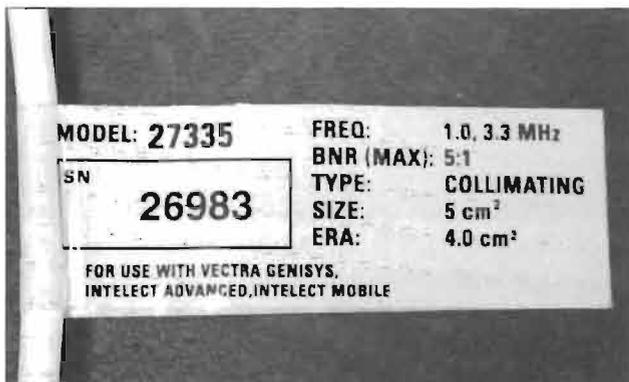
FDA Labeling Requirements for Therapeutic Ultrasound. The sound head pictured here is capable of producing an output frequency of 1 or 3.3 MHz and has an effective radiating area of 4.0 cm². Note that the BNR is listed as 5:1 for both outputs. The "Max." indicates that this was the maximum BNR found in a sample of sound heads.
